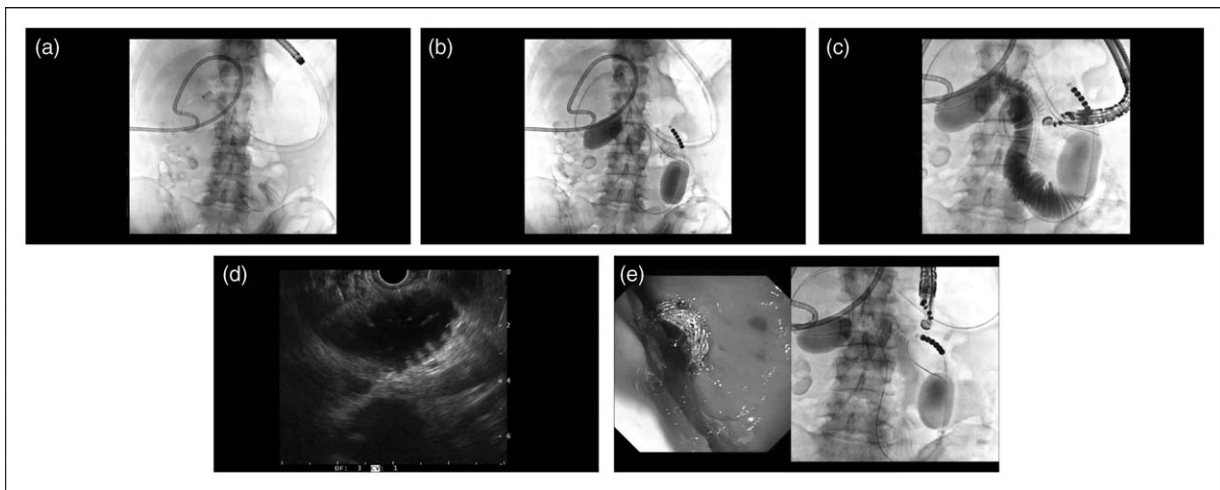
(a) A double-balloon enteroscope being withdrawn after advancing a guidewire downstream into the jejunum. (b) The two balloons of the novel double-balloon occlusion catheter are inflated securing a segment of small bowel between them. (c) Contrast and methylene blue used to fill this segment of small bowel between the two balloons. (d) EUS then used to identify this segment of jejunum, and (e) the lumen apposing stent is deployed. EUS, endoscopic ultrasound.
